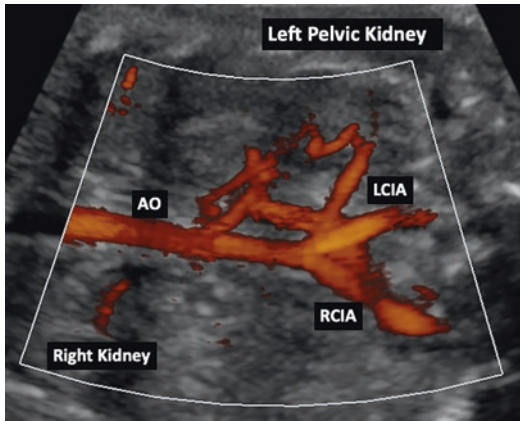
Power Doppler image of renal vascular supply of a fetal pelvic kidney. The Doppler image is confirmatory of B-mode finding. Note monochromatic color flow with no demonstrable angle effect. *AO* Aorta, *RCIA* Right common iliac artery, *LCIA* Left common iliac artery
